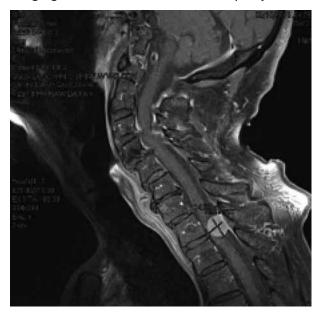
Sagittal T2-weighted image showing an extramedullary mass at T_1 - T_2 with spinal cord compression in addition to marked cervical spine degeneration and marked stenosis.
